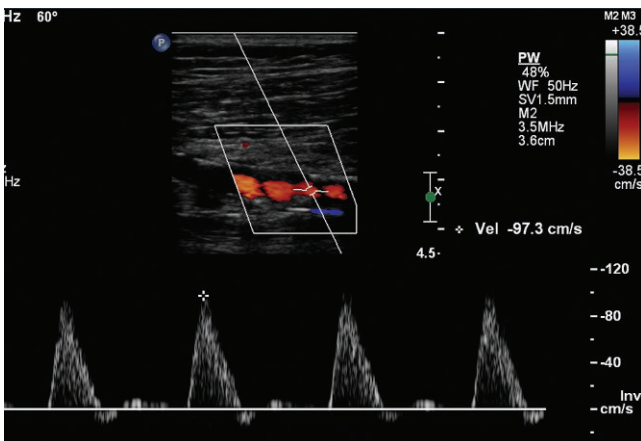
Color duplex Doppler of the superficial femoral artery demonstrates plaque and mild narrowing in the artery. The waveform shape is normal multiphasic (triphasic) with minimal spectral broadening in systole. The velocity in the vessel is within normal limits.
